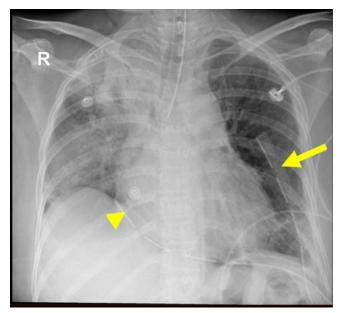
Chest X-ray on POP Day 4 with resolved hydropneumopericardium, showing the two drains, in the pleural space (arrow) and intrapericardial space (arrowhead).
